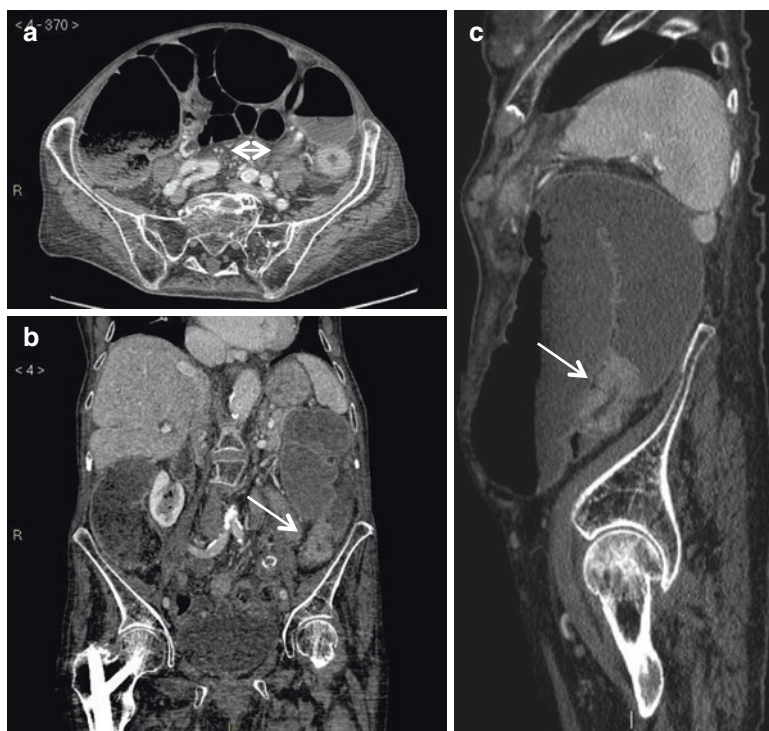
Multiplanar reconstructions of a CT scan with the use of intravenous medium contrast showing a sigmoid colorectal cancer: substantial colonic distention (a: the *white arrow* indicates the small bowel lumen), caused by a stenosing lesion (b, c: *white arrow*), in the setting of competent ileocecal valve. Wall thickening with contrast enhancement at cancer site is evident in all planes
